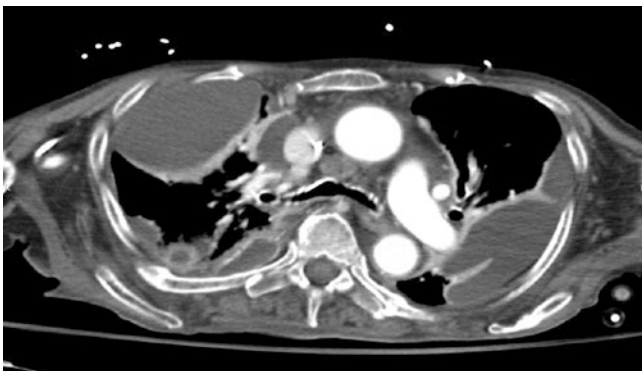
CT scan demonstrating loculated fluid collections suggestive of empyema
